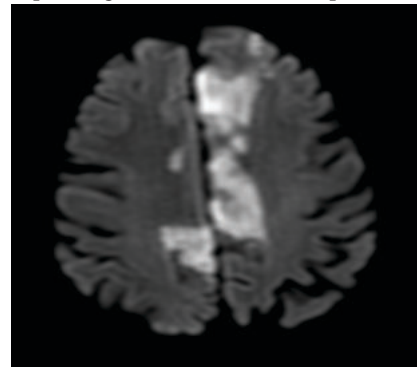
DWI images showing areas of diffusion restriction in bilateral ACA territory- suggestive of acute infarct
